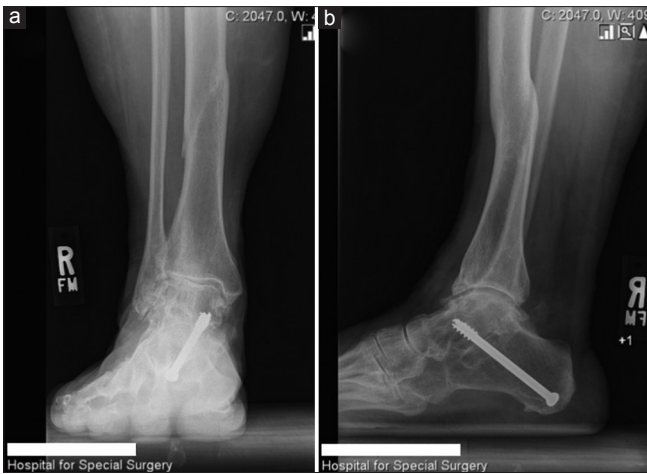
(a) Weight-bearing anteroposterior radiograph (right ankle) showing evidence of talotibial osteoarthritis, talar valgus tilt, and distal portion of the previously healed tibial segmental fracture. (b) Weight-bearing lateral radiograph showing tibial recurvatum deformity and a screw from previous subtalar and calcaneocuboid fusion
